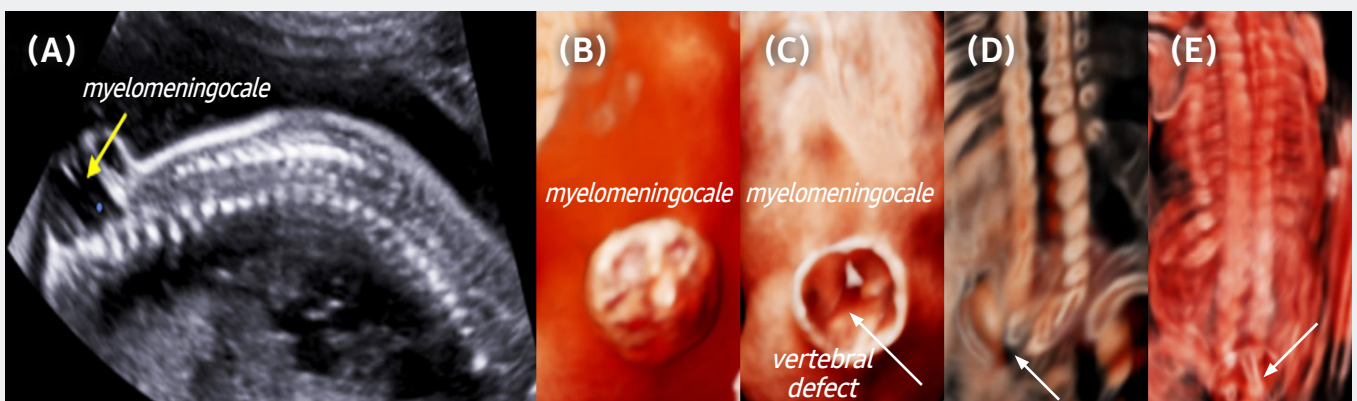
Open spina bifida : 2D ultrasound clearly visible the vertebral defect with myelomeningocele in the sagittal scan (A), CrystalVue™ with different complexity: defect of the spine in which part of the spinal cord and meninges (white arrow) are exposed through a gap in the backbone (B-E).
